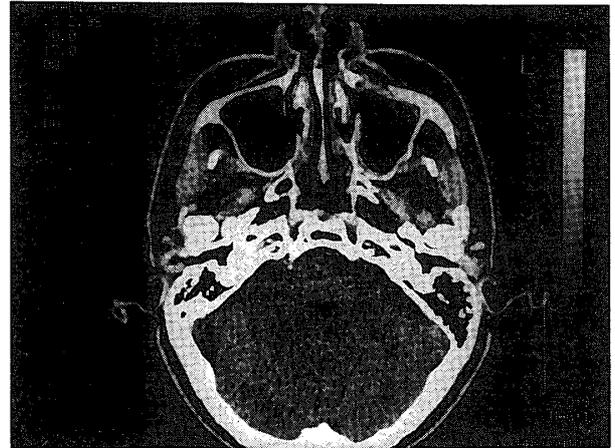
Computed tomograph 2 years after the surgery showing no sign of recurrence.
